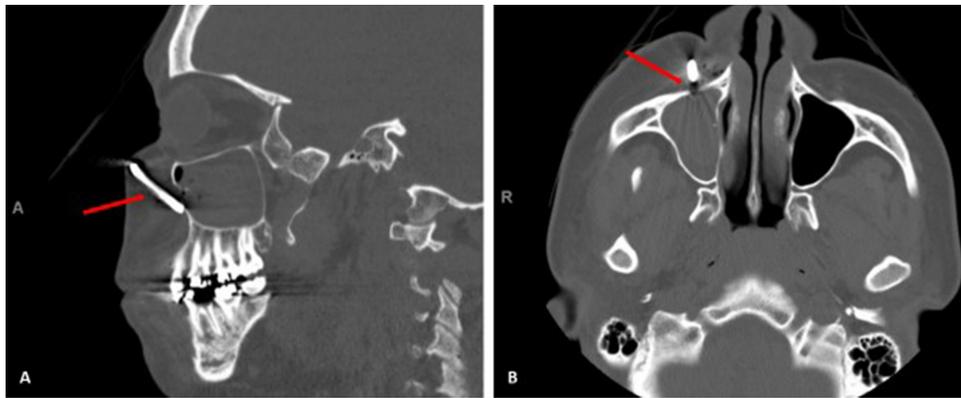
AP (A) and transverse (B) CT views revealing comminuted fracture of anterior wall of the right maxillary sinus.
